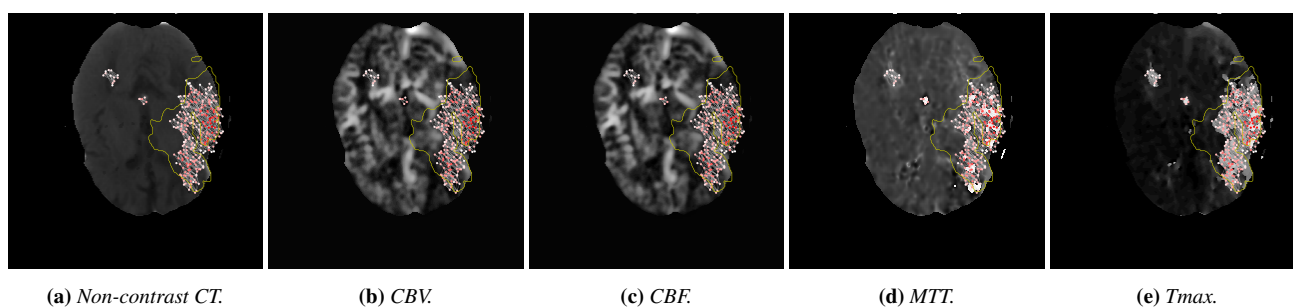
Results of the presented methods. The presented visualization was applied to a) a non-contrast CT and several parameter maps resulting from perfusion CT from b) to e). b) shows the applied visualization applied to cerebral blood volume, c) to cerebral blood flow, d) to mean transit time and e) to time to peak.
